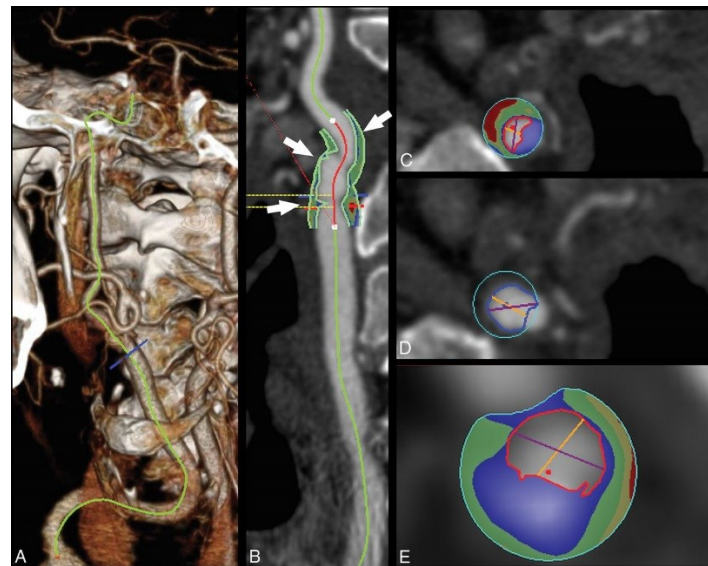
Plaque component analysis of a 75-year-old man with a transient ischemic attack using CT image reconstruction software. Volume-rendered image where the carotid artery is traced (A). Reconstruction post-processed image (B). Plaque cross-sectional identification positioned in (B), as indicated by white arrows (C), (D) and (E), where the lumen is indicated by a red contour, the lipid component by the red color, mixed tissues in green and calcium in blue. Adapted from [57].
